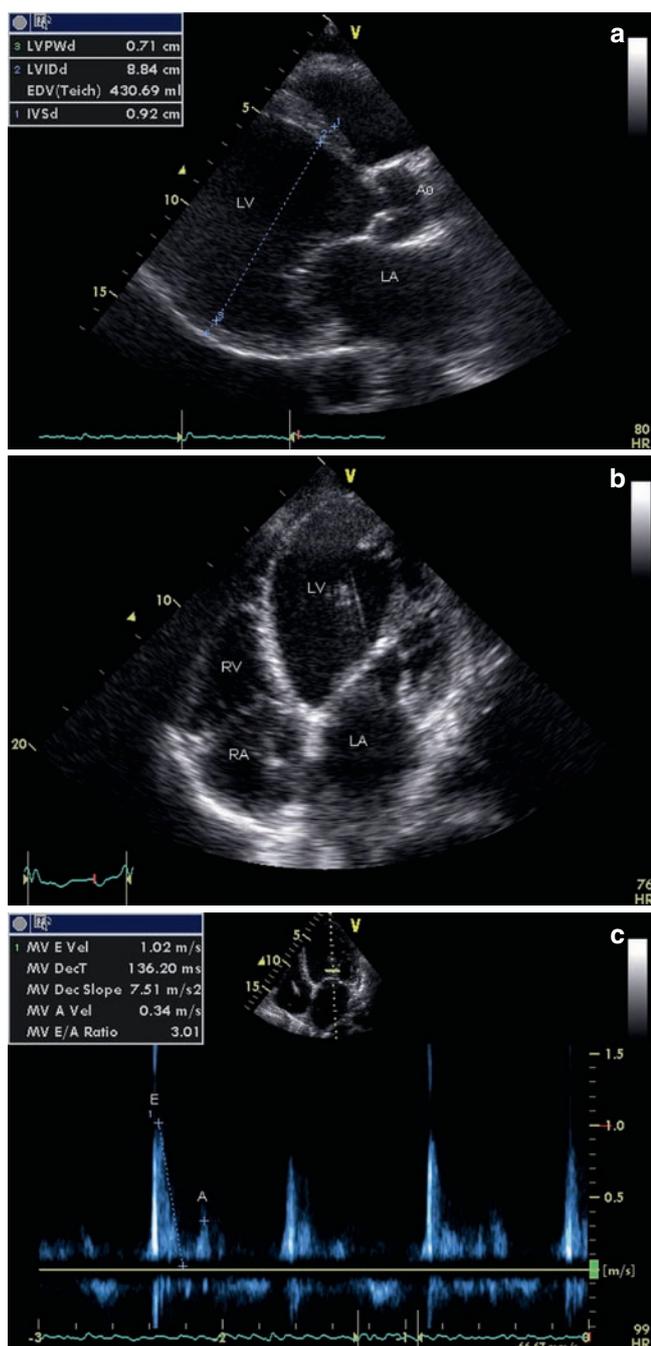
(a) 2D parasternal long-axis view of a patient with biopsy-proven cardiac sarcoidosis. The appearance is typical of a dilated cardiomyopathy with globally reduced contraction. The end-diastolic dimension (LVEDd) is increased and there is normal thickness of the posterior wall (LVPWd) and the interventricular septum (IVSd). LV: left ventricle; Ao = aorta; and LA: left atrium. (b) 2D echocardiogram of an apical four chamber showing an LV that is significantly dilated and spherical in shape. This patient had endomyocardial biopsy-proven sarcoidosis, but the appearance is indistinguishable from a typical dilated cardiomyopathy. RV: right ventricle; RA: right atrium; and LA: left atrium. (c) Pulse-wave Doppler of mitral valve (MV) inflow in a patient with dilated cardiomyopathy due to sarcoidosis showing a restrictive filling pattern with a E (early-diastolic filling) to A (late-diastolic filling due to atrial contraction) ratio of greater than 2 and a short DT
